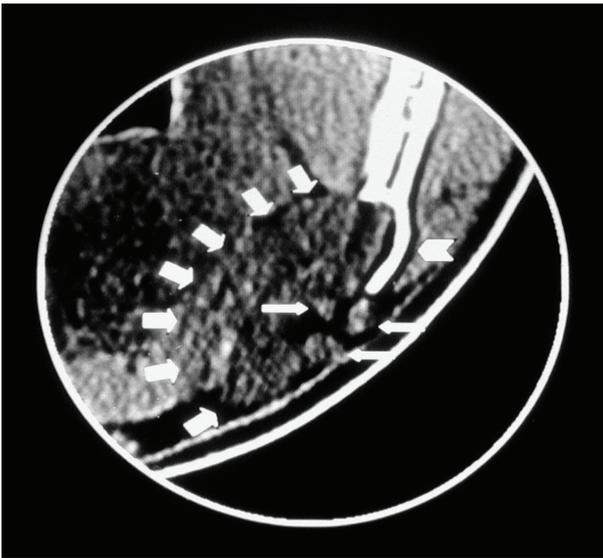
CT image: soft-tissue window and coronal view, in which the expansion of the mandibular buccal cortex (arrow head), the submandibular gland (large arrows), and some lymph nodes (small arrows) can be seen.
